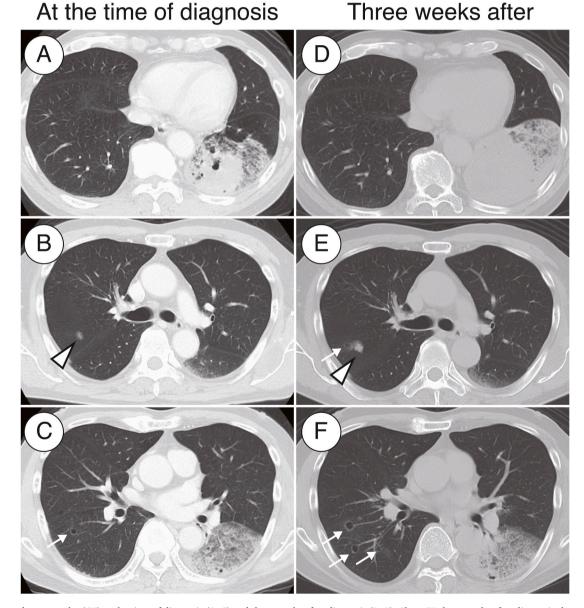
Computed tomography (CT) at the time of diagnosis (A–C) and three weeks after diagnosis (D–F). Chest CT three weeks after diagnosis showed increases in size of the ground-glass opacity nodule (arrowhead) in the right S2 segment, multiple thin-walled cystic lesions (arrows) in the right lung, and the mass lesion in the left lower lobe.
